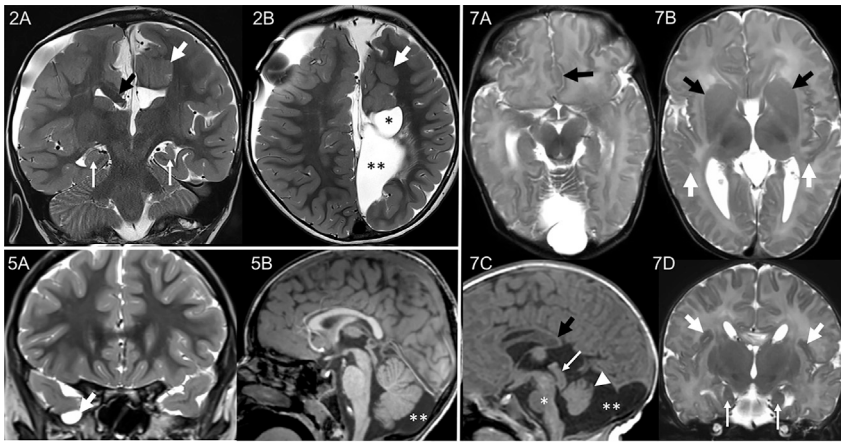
MRI Findings in Individuals 2, 5, and 7
